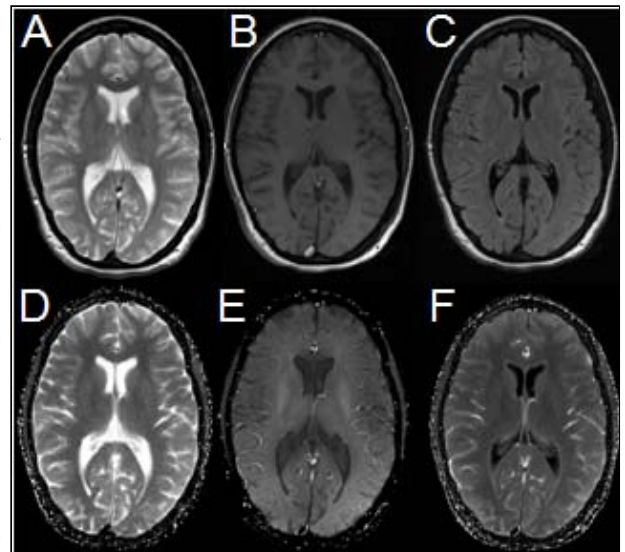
Example (A) T2w TSE, (B) T1w SE, (C) FLAIR TSE, (D) synthetic T2w TSE, (E) synthetic T1w SE, and (F) synthetic FLAIR TSE.
